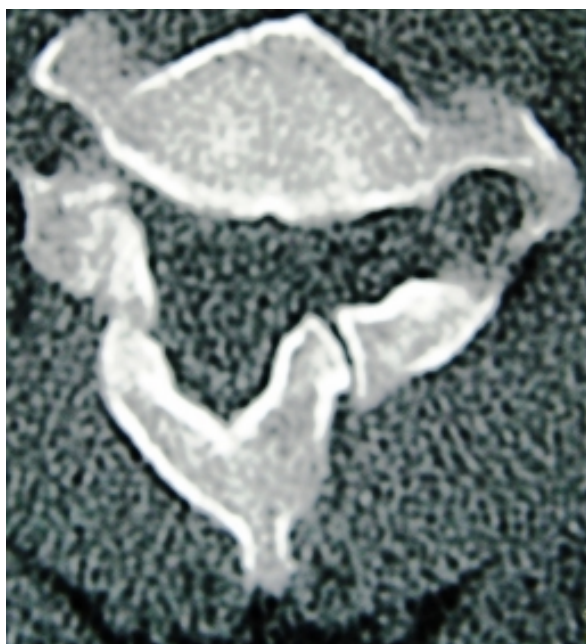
CT axial section showing fracture involving left lamina of C2 Vertebra with pseudoarthrosis and causing segmental canal stenosis
